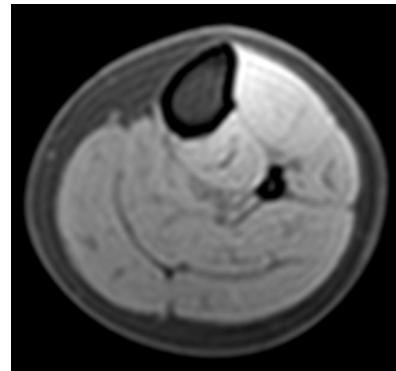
A typical MRI image we will be acquiring through the calf muscles.
